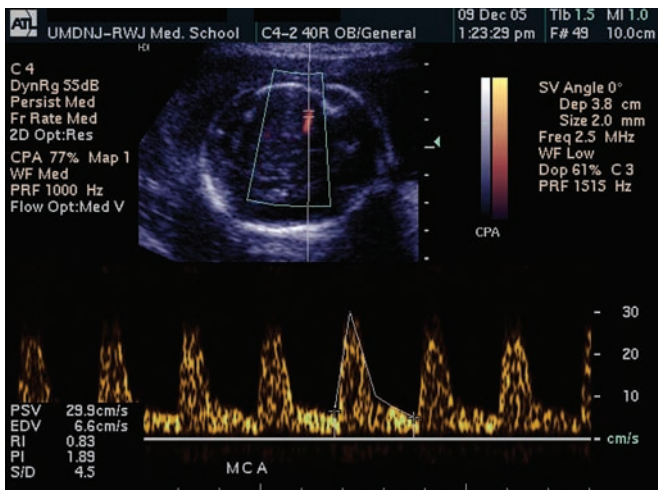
Normal middle cerebral artery Doppler waveform. The systolic/diastolic ratio is high (4.5), consistent with normal high-resistance pattern.
